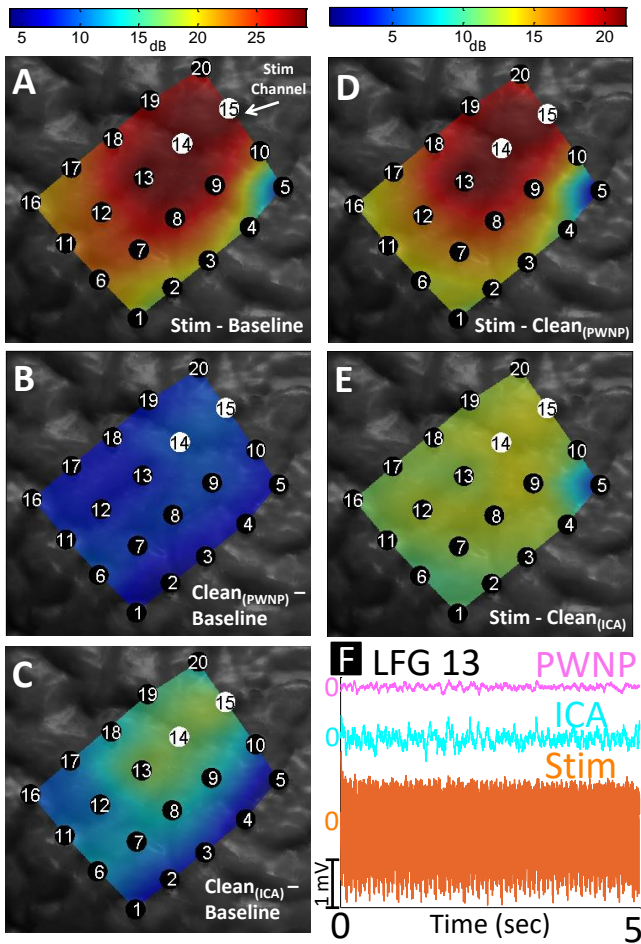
Power difference maps showing the effect of the PWNP and ICA procedures. Power differences were calculated for each electrode by subtracting the integrated power (Eq. 2) of the second condition from that of the first condition (see Section II-D). These values were interpolated across the grid, color-coded, and super-imposed on the MR-CT co-registered image. Since the signals at the stimulation channels were saturated, we imputed values for these electrodes with highest difference in power for each image. The difference in the integrated power between stimulation-contaminated and baseline data (A), PWNP-cleaned and baseline data (B), ICA-cleaned and baseline data (C), stimulation-contaminated and PWNP-cleaned data (D), and stimulation-contaminated and ICA-cleaned data (E). Fig. 3F shows the time domain before and after the cleaning process.
